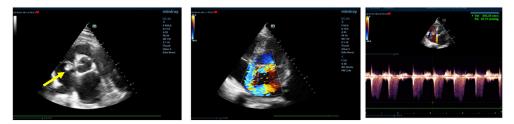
c.2. Moderate tricuspid regurgitation in a case with concomitant left and right heart pathology: left-tricuspid valve endocarditis; a large vegetation attached to tricuspid ring (arrow) (2D, parasternal short axis at great vessel level); middle-severe asymmetric mitral regurgitation (color Doppler focused on left chambers, 4-chambers view); right-tricuspid regurgitation and calculation of right interatrial-ventricular gradient Pmx=47 mmHg, CW Doppler, 4-chambers view).
